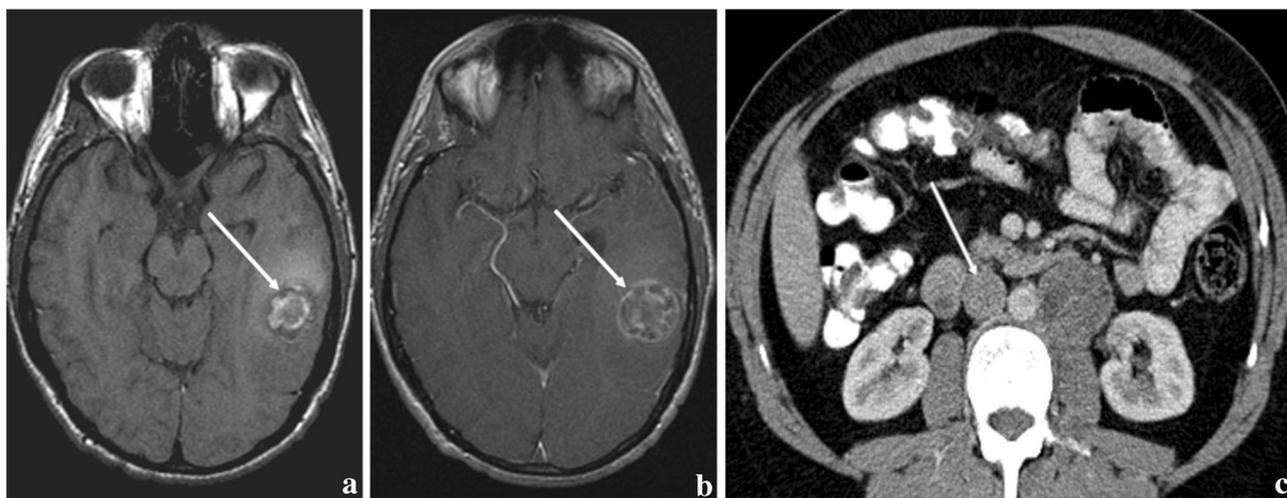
32-year-old male with metastatic choriocarcinoma. At the time of presentation, markedly elevated HCG (approximately 7000 mIU/mL) raised clinical suspicion for choriocarcinoma. FLAIR (a) and T1w post-gad (b) MRI images reveal vasogenic edema
